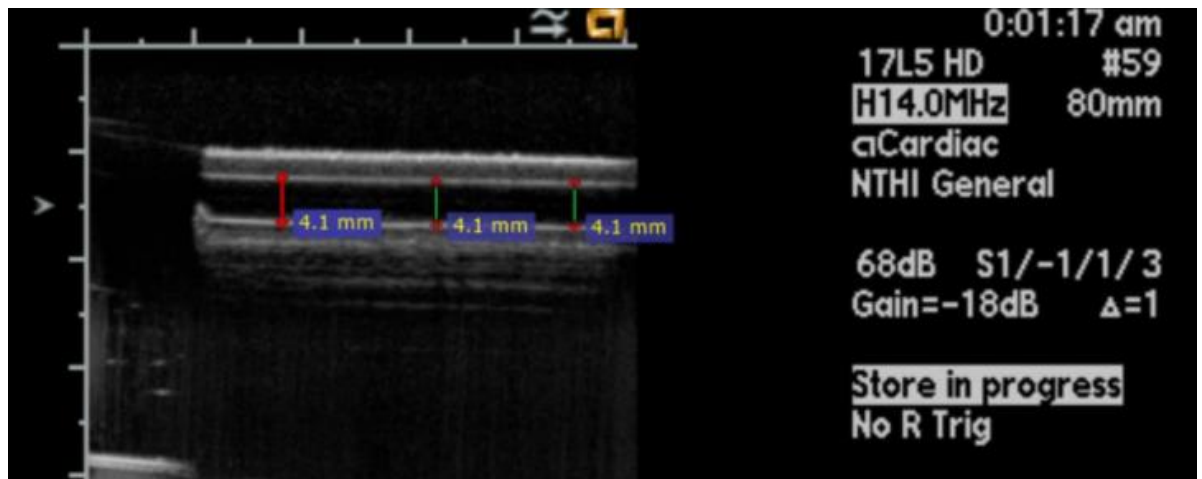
Ultrasound measurement of the brachial artery diameter
